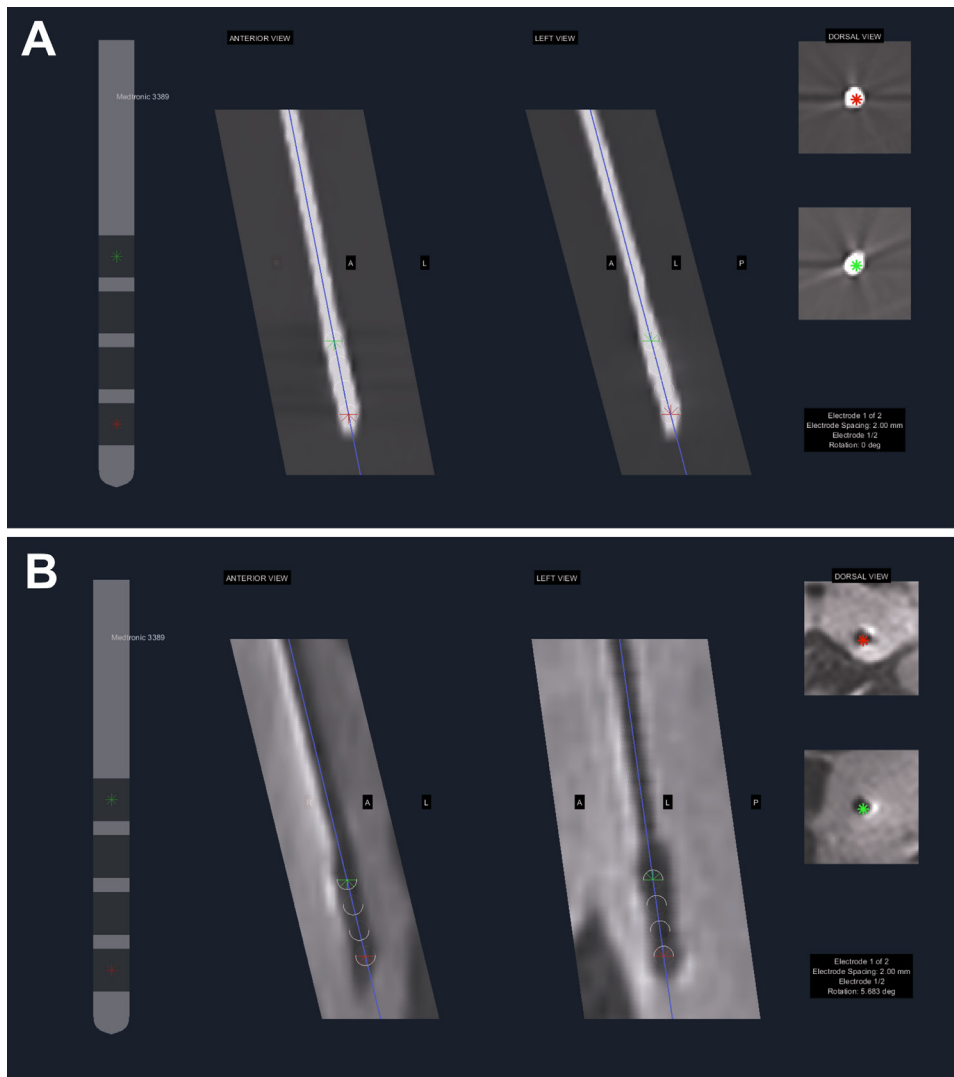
Examples of electrode models matched onto electrode artifacts visible on post-operative CT (A) and MRI (B) as visualized in Lead-DBS. From left to right: Electrode model (here Medtronic 3389) plotted onto the electrode artifact as visible on two orthogonal planes of a probe eye view of the post-operative CT (A) or MRI (B). The upper- and lowermost contacts of the electrode model are additionally plotted in the axial plane to allow for an optimal adjustment of the pre-localized position of the electrode model in all three axes.
